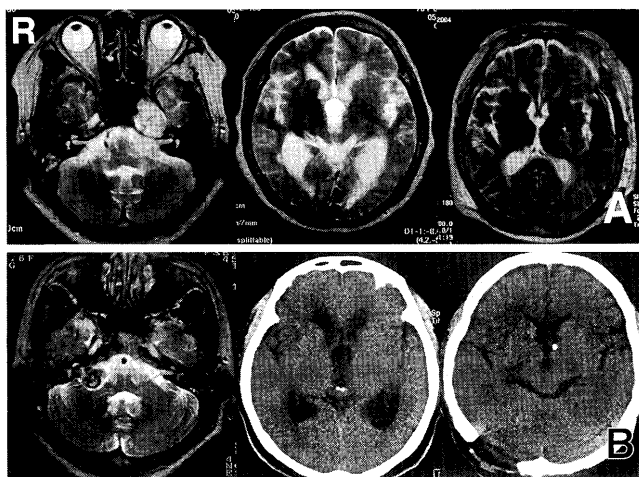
A: Case 1. T₂-weighted magnetic resonance images before shunt surgery (left, center) showing a heterogeneous mass lesion (40 × 30 mm) in Meckel's cave in the left middle fossa and enlargement of the ventricle. T₂-weighted magnetic resonance image after surgery (right) showing decreased size of the ventricle. B: Case 2. T₂-weighted magnetic resonance image (left) and computed tomography scan (center) before shunt surgery showing a heterogeneous mass lesion in the right cerebellopontine angle and enlargement of the ventricle. Computed tomography scan after surgery (right) showing decreased size of the ventricle.
